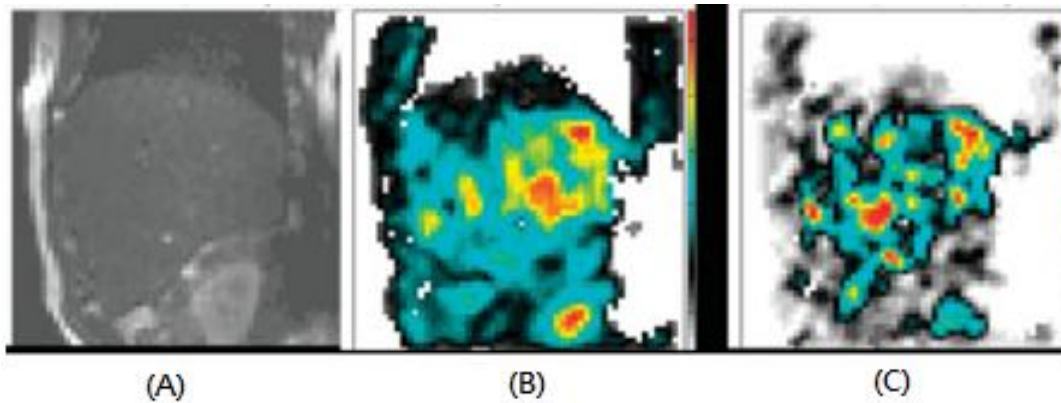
MRE images of patient with cirrhosis. (a) shows the ROI of liver in MRI, (b) represents elasticity map of liver fibrosis and (c) represents the viscosity map of liver fibrosis. (Huwart et al. 2006)
